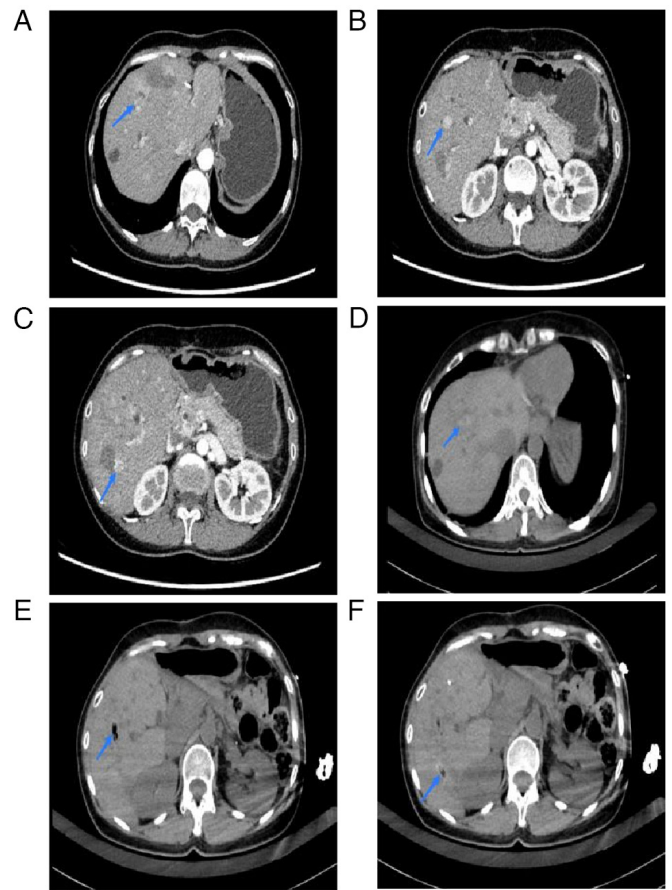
CT acquired at postoperative month 24. CT images (A-C) before and (D-F) after microwave ablation of residual liver metastases. CT, computed tomography (arrow indicates the liver metastasis lesion location).
